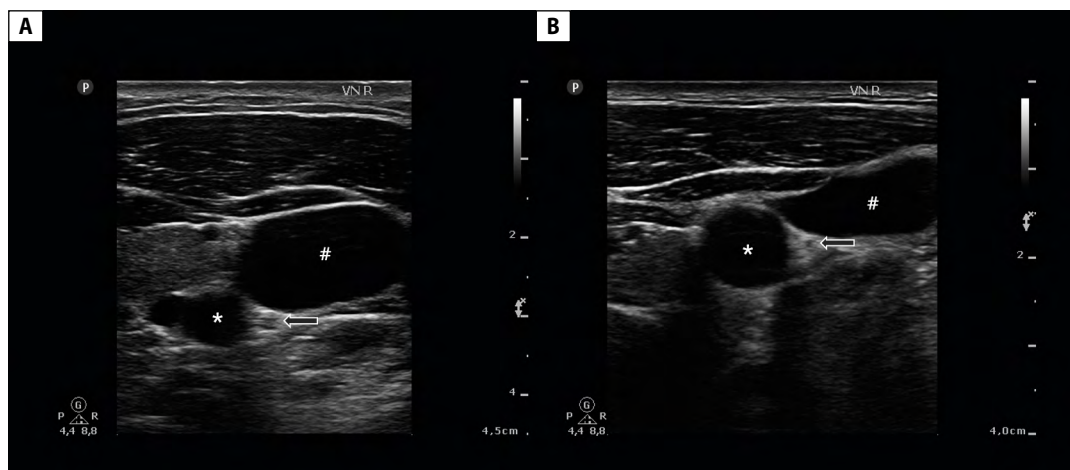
Example VN ultrasound images of two individuals (authors' own material): A – subject without neurodegenerative disease (58-year-old male), VN CSA 3.4 mm²; B – patient with advanced PD (65-year-old male, disease duration 11 years, H&Y stage 4), VN CSA 1.6 mm². Outlined arrow – vagus nerve; * – common carotid artery; # – internal jugular vein; VN – vagus nerve; CSA – cross-sectional area; H&Y – Hoehn & Yahr stage
